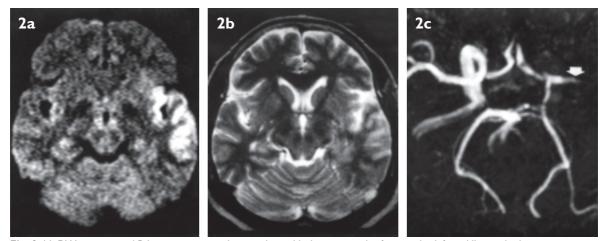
(a) DW imaging at 4.5 hours post-ictus shows indisputable large cortical infarct in the left middle cerebral artery territory, graded glaringly obvious on conspicuity scoring. (b) This is deemed obscure on T2-weighted scan. (c) MR angiography reveals abrupt cut-off of the MI segment of the left middle cerebral artery (arrow).
